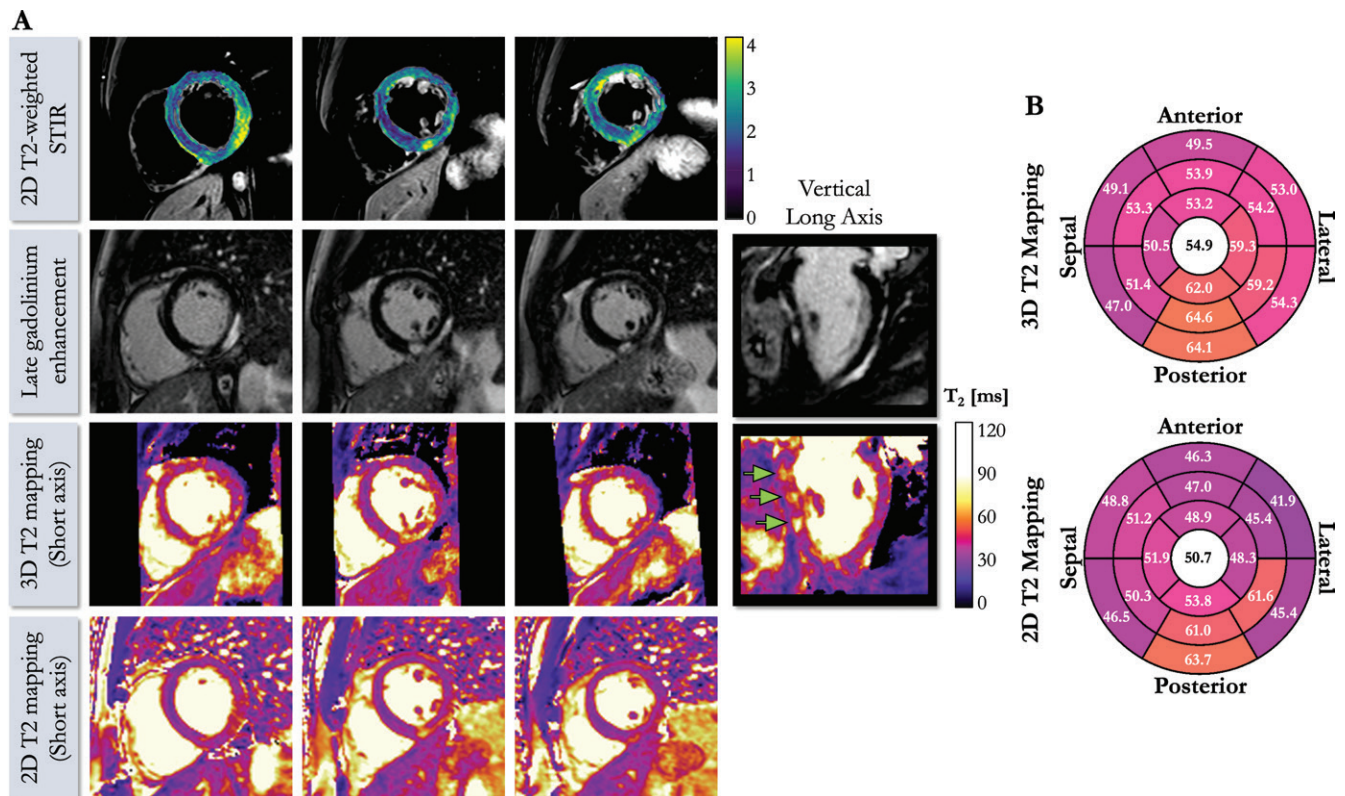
A, Cardiac MRI scans in 41-year-old male participant (cohort 2) with suspected cardiac sarcoidosis. Free-breathing three-dimensional (3D) whole-heart T2 mapping acquisition time was 7 minutes 8 seconds. Cardiac cine acquisitions reveal slightly reduced left ventricular ejection fraction (46%). Dense epicardial-to-midwall enhancement of basal to midinferior and lateral walls can be observed, which are typical findings of acute myocarditis. Vertical long axis demonstrates patchy focal midwall regions of enhancement (arrows). B, Three-dimensional and two-dimensional (2D) T2 maps. Three-dimensional map shows an increase in T2 values (msec) in regions of tissue injury, corresponding to elevation in signal intensity on 2D T2-weighted STIR images (signal intensity, 2.1). This T2 elevation is less pronounced and appreciable on 2D T2 maps because of partial volume effects. STIR = short inversion time inversion recovery.
